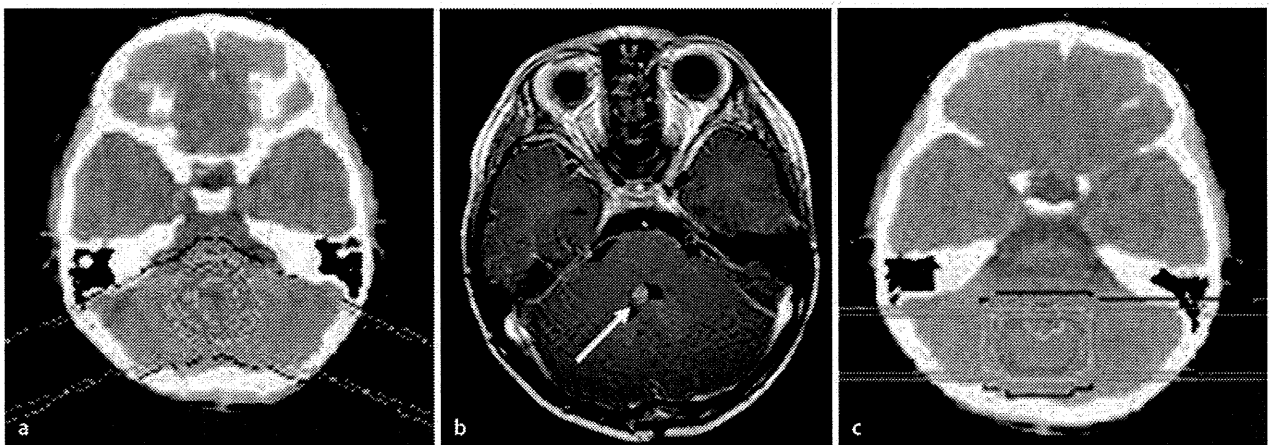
▲ Imaging for a patient treated with reirradiation with PBT. a Isodose curves for initial PBT representing 100-10% of the prescribed dose at 10% intervals. b Postcontrast T1-weighted MRI before reirradiation. c Isodose curves for the second treatment with PBT representing 100-10% of the prescribed dose at 10% intervals
